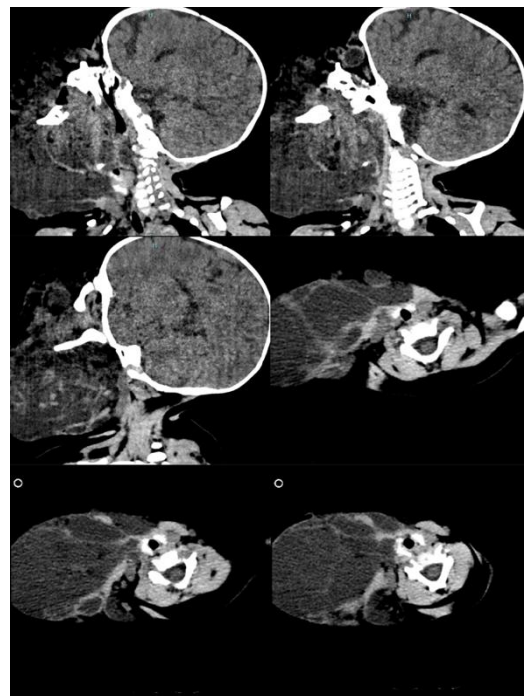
Head and Neck CT Scan.
